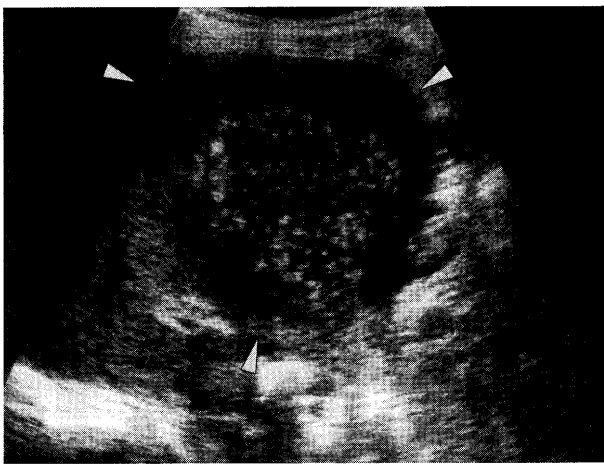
Ultrasonography performed on 1 day after admission revealed well distinct low echoic mass with numerous strong echoes in the anterior segment of the liver.
